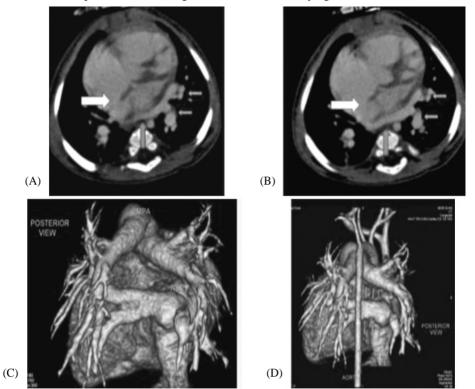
(A) coronal reconstructed CT image showing the four pulmonary veins (white arrows). (B) Axial MDCT image showing large ASD (arrow). (C) 3D reformatted image showing the right and left superior pulmonary veins draining into the single vertical vein. (D) 3D reformatted image showing the vertical vein (four arrows), which drains pulmonary veins into dilated coronary sinus (arrow) to right atrium (arrow).
